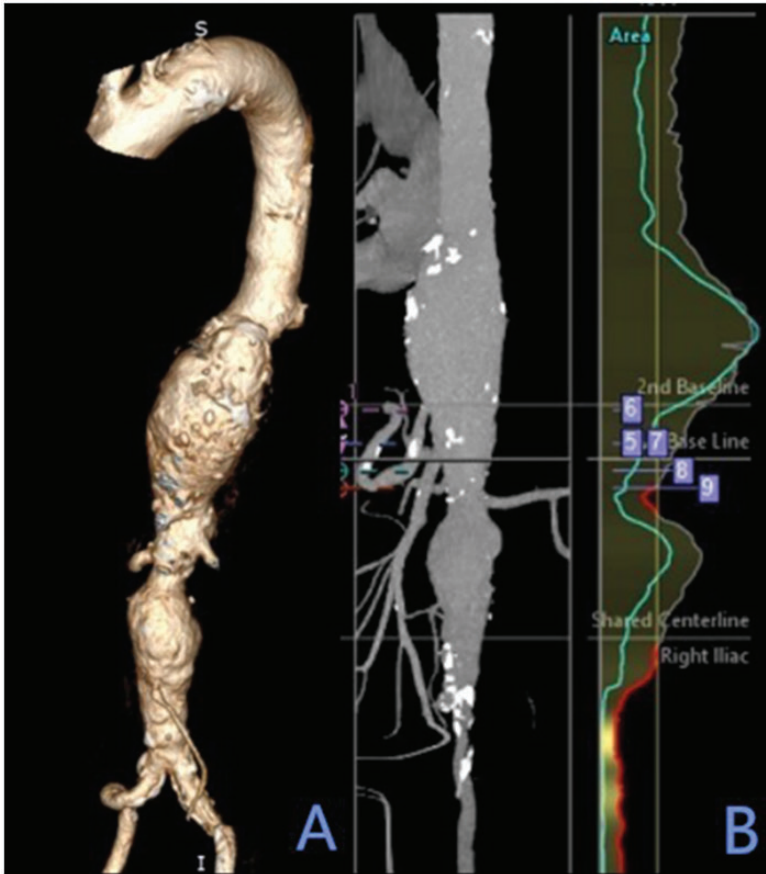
Preoperative computed tomographic angiography of a 66-year-old male who complained of abdominal bloating and pain for 2 days: (A) three-dimensional image of the aorta and iliac artery; (B) two-dimensional image of the same structures. A thoracoabdominal aortic aneurysm (Crawford type III) from the distal descending aorta to the suprarenal abdominal aorta that involved the celiac axis, accompanied with an occlusion of the left subclavian artery, was diagnosed. The colour version of this figure is available at: <http://imr.sagepub.com>.
